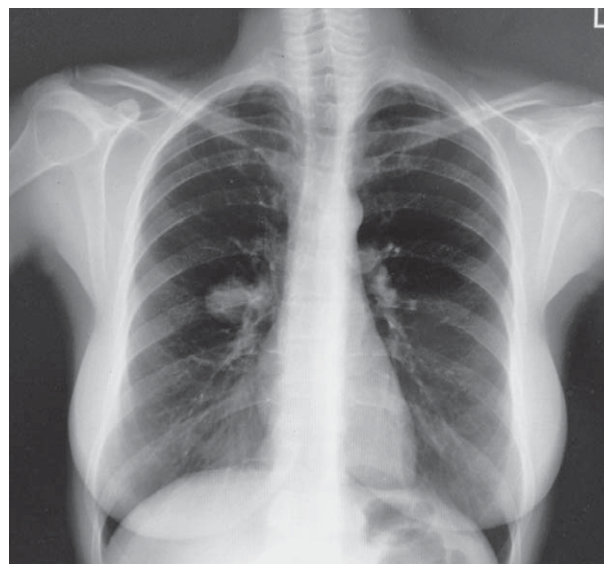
Chest x-ray showing hamartoma of the right lung.
